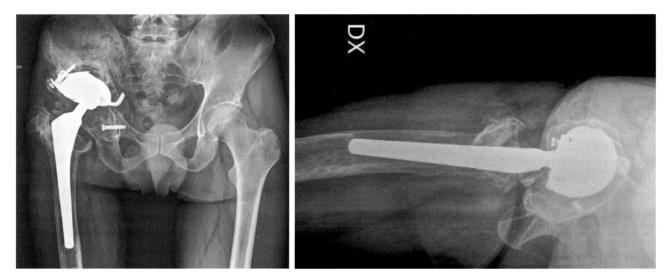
/B. Preoperative x-rays. Stage IV acetabular bone loss after reconstruction cage loosening.
